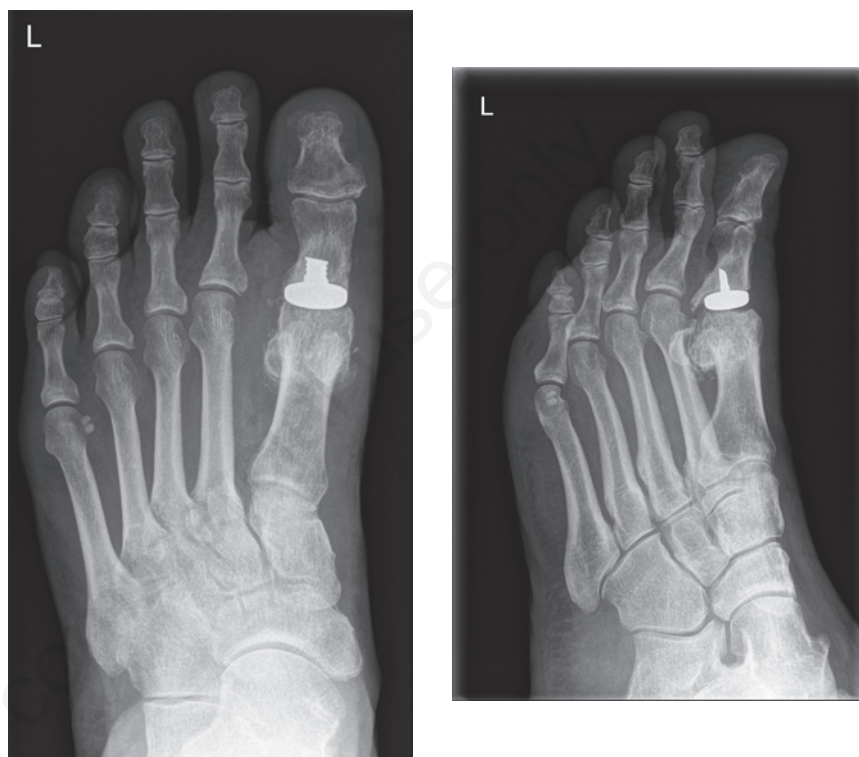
Postoperative radiographs showing a correct prosthetic fitting.
